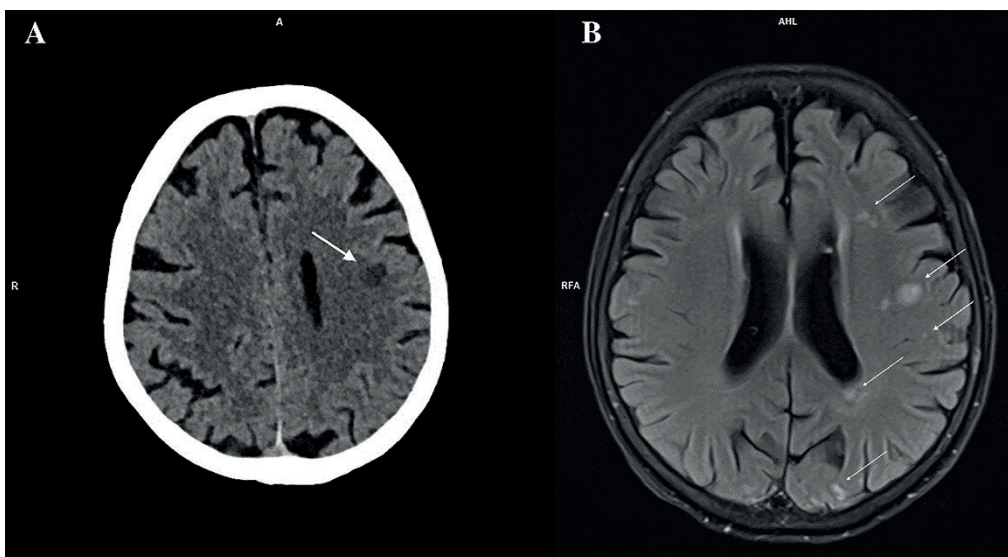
Head computed tomography showing an ischemic stroke in the left frontal lobe (arrow) (A). Brain magnetic resonance imaging showing multiple ischemic lesions in different vascular territories (arrows) (B).
